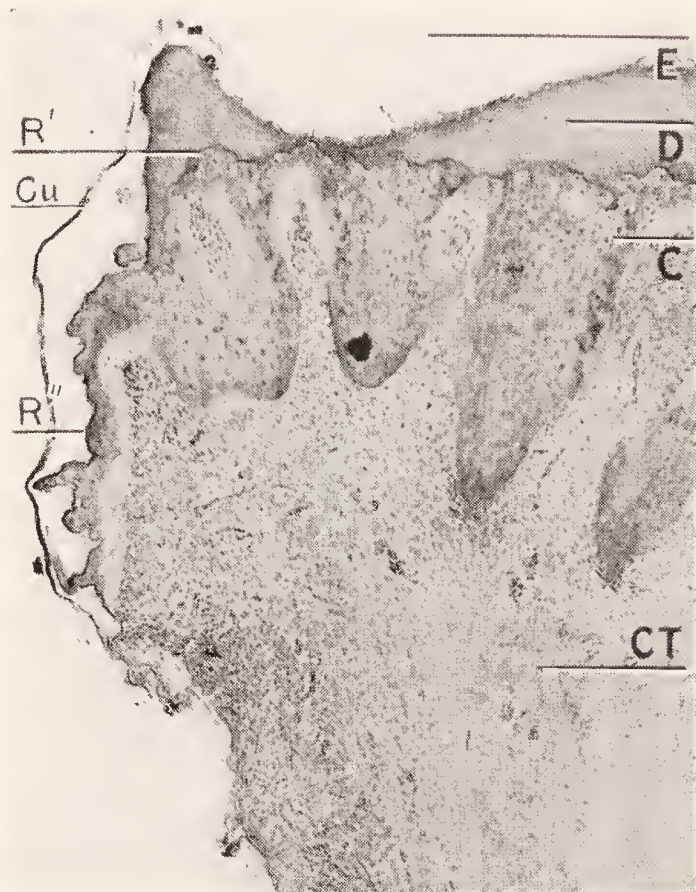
Reparative formation of bone on the inside of the resorbed crown of an upper lateral incisor. Same case as shown in Figs. 213 and 214. D, dentin; E, enamel; Cu, cuticle; R', line of resorption in the dentin; R'', enamel resorption; C, deposits of bone on the resorbed surface of enamel and dentin; CT, connective tissue. (Mueller, Jour. Am. Dent. Assn.)
